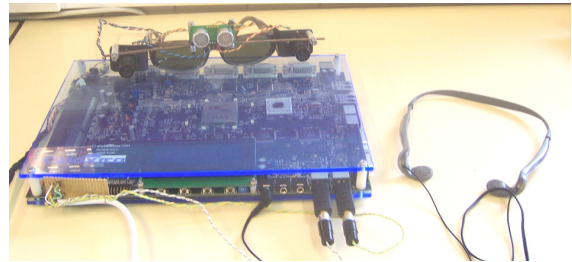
Experimental hardware prototype composed by two cameras, an ultrasonic range finder, headphones and a RC300 board.
